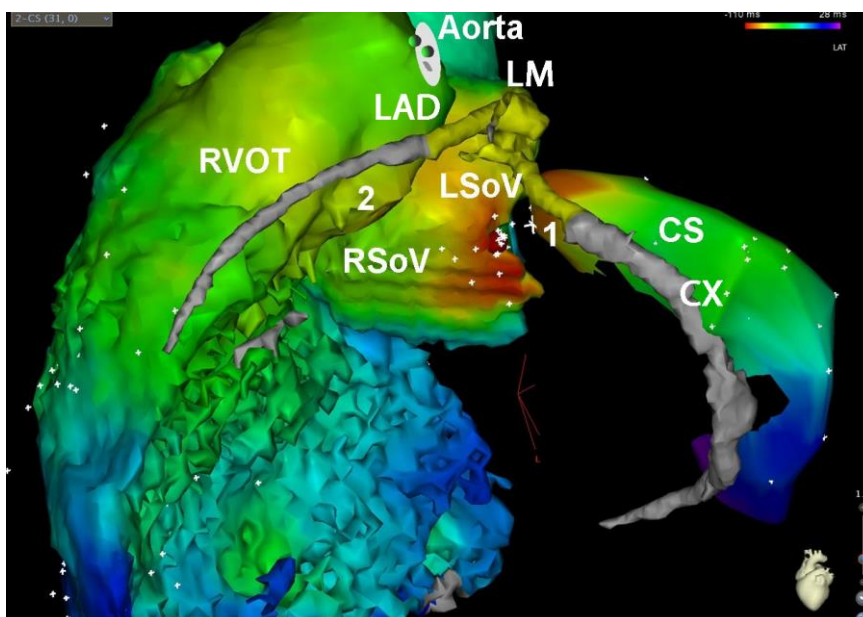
3D CT image integration into the electroanatomical mapping system. The arrhythmia was eliminated by RFCA from the left sinus of Valsalva (red dot) in safe distance from the left main coronary artery(LM). The 3D CT image integration and the visualisation of the coronary arteries provided reliable and accurate anatomic information and thus coronary angiography was unnecessary. RVOT, right ventricular outflow tract; LSoV, left sinus of Valsalva; RSoV, right sinus of Valsalva; CS, coronary sinus; LM, left main coronary artery; LAD, left anterior descending coronary artery; CX, circumflex coronary artery.
